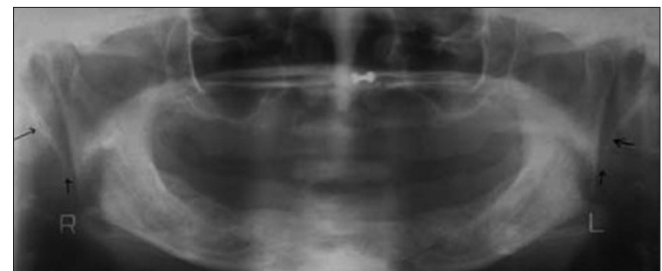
Orthopantomogram showing bilateral elongation of styloid process^[46]
